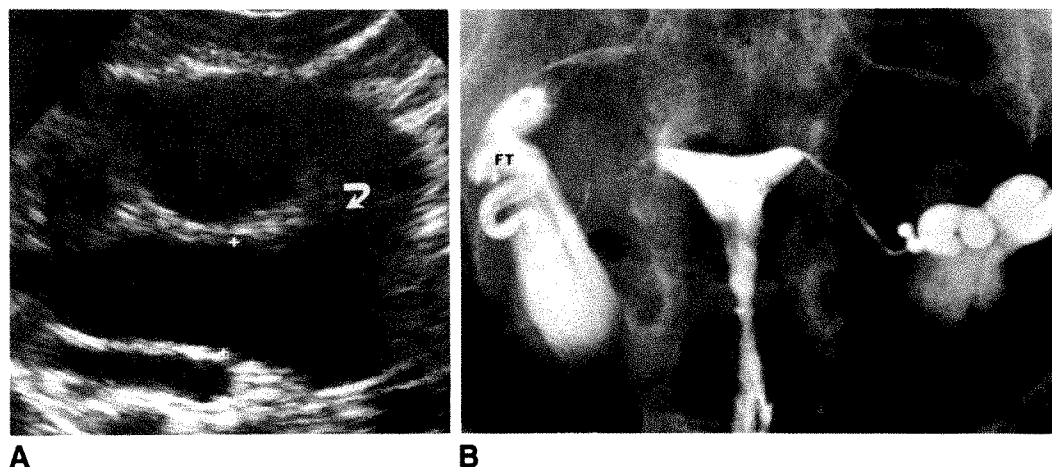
A, Oblique endovaginal sonogram of right adnexal region shows a 2.7-cm tubular structure with a folded appearance (curved arrow).
